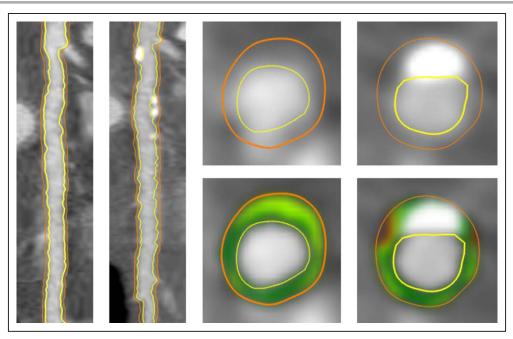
Example of quantitative computed tomography angiography (CTA) analysis for a statin-taking patient. Representative case showing the impact of statin use on coronary artery disease progression. Although initially no coronary calcification was present at quantitative CTA analysis, extensive calcification had occurred after 8 y of follow-up. Red indicates necrotic core tissue, light green indicates fibro-fatty tissue, dark green indicates fibrous tissue, and white indicates dense calcium tissue.
